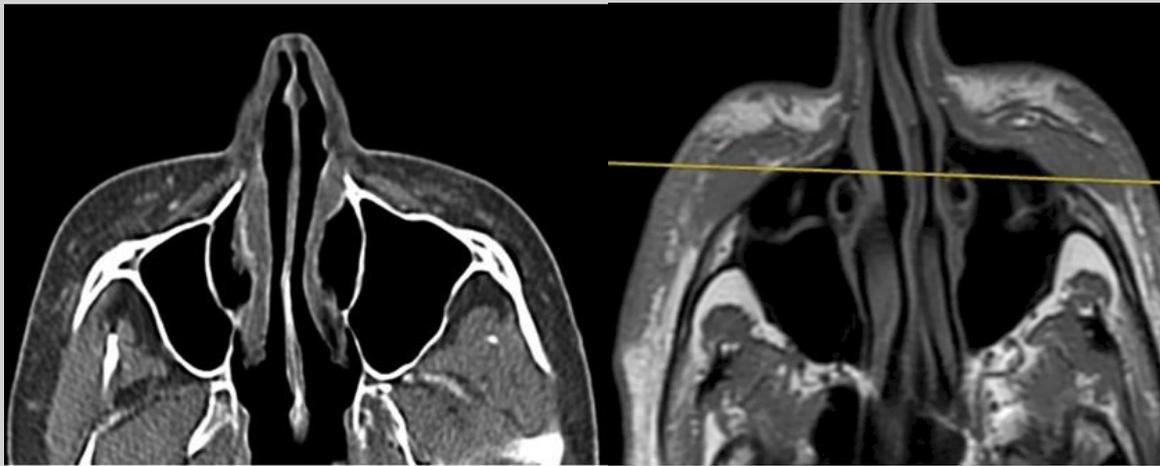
Axial CT image shows irregular bilateral soft-tissue attenuation with surrounding cystic fibrosis in the subcutaneous tissues of the cheeks. On MRI, hypointense material on T1-weighted sequences is observed within the subcutaneous cellular tissue of both malar regions.
